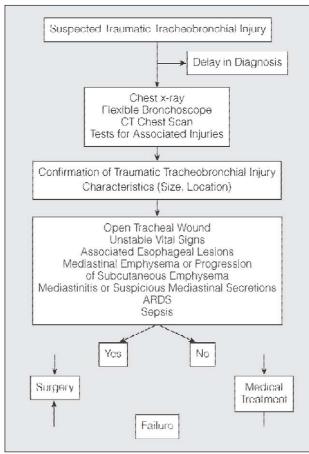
Therapeutic algorithm for traumatic tracheobronchial injuries. CT indicates computed tomography; ARDS, acute respiratory distress syndrome.
